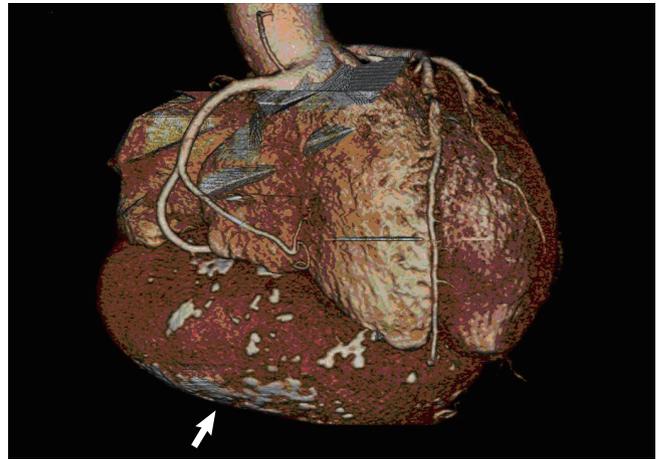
Reconstructed 3D-computed tomography. The left ventricular pseudoaneurysm is indicated by an arrow.
